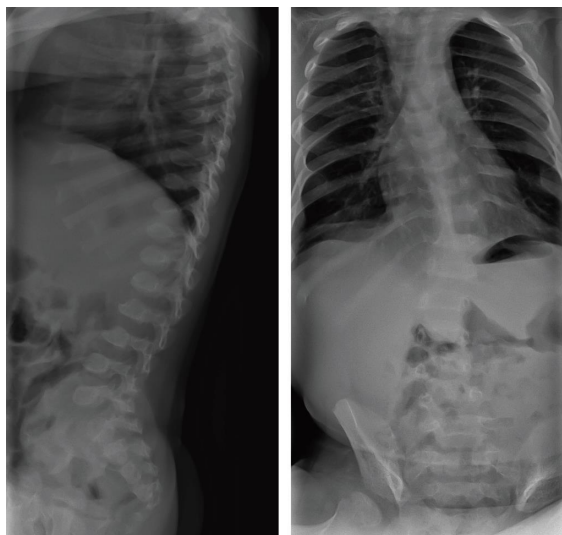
Spinal radiograph showing thoracolumbar scoliosis, ovoid thoracic vertebrae, and anterior hypoplasia of the lumbar vertebral bodies.
